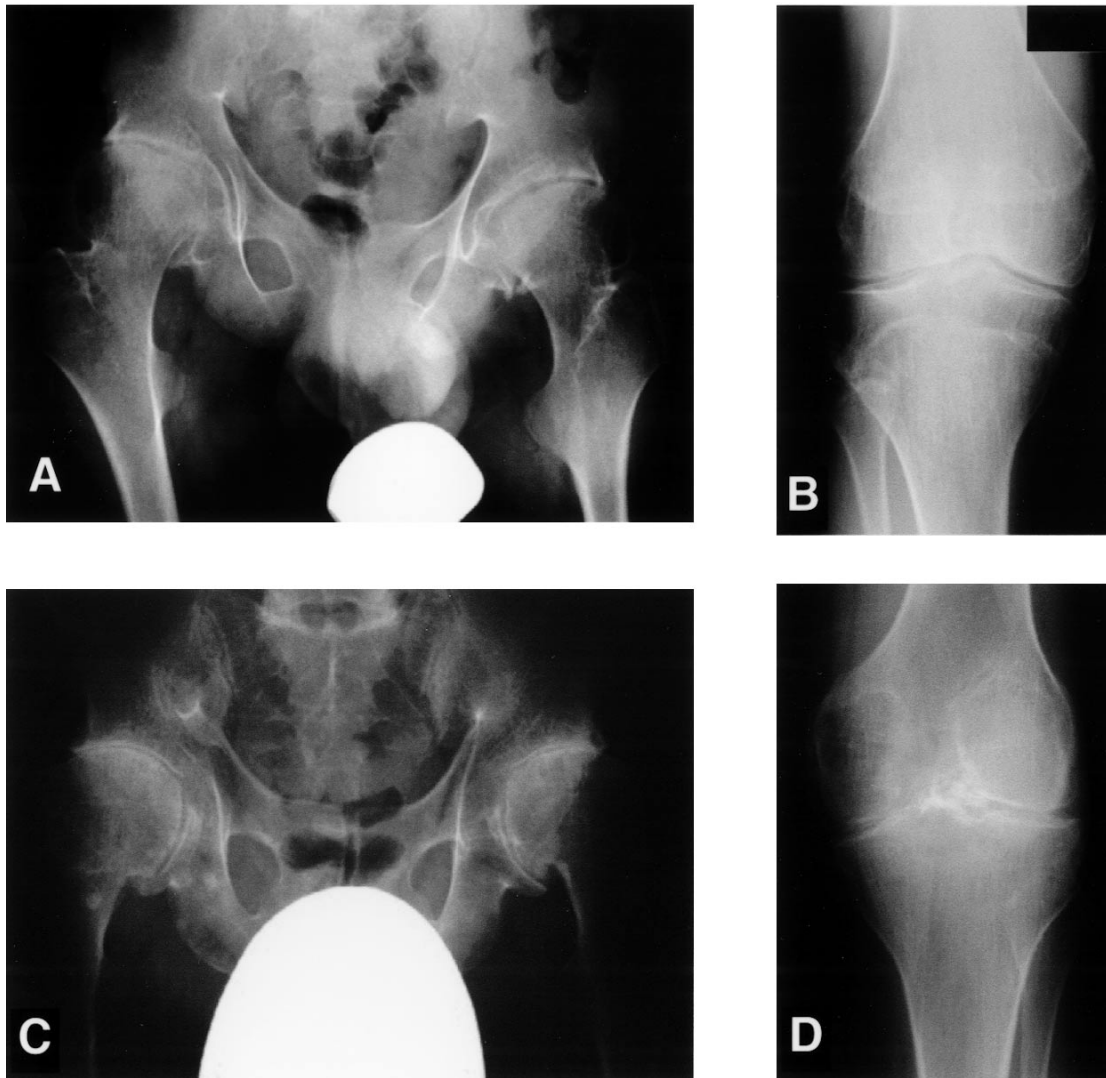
A. Anteroposterior (AP) radiographs of the hips of a representative patient reveal flattening of the femoral head and destructive changes. B. AP radiographs of the knee of a representative patient show flattening of the femoral condyles and destructive changes. C. AP radiographs of the hips of the patient's father, who had more advanced arthritic changes. D. AP radiographs of the knee of the patient's father, with more advanced changes.
